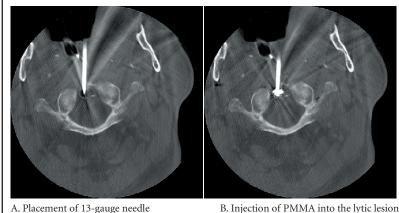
CT images of C spine during treatment.
